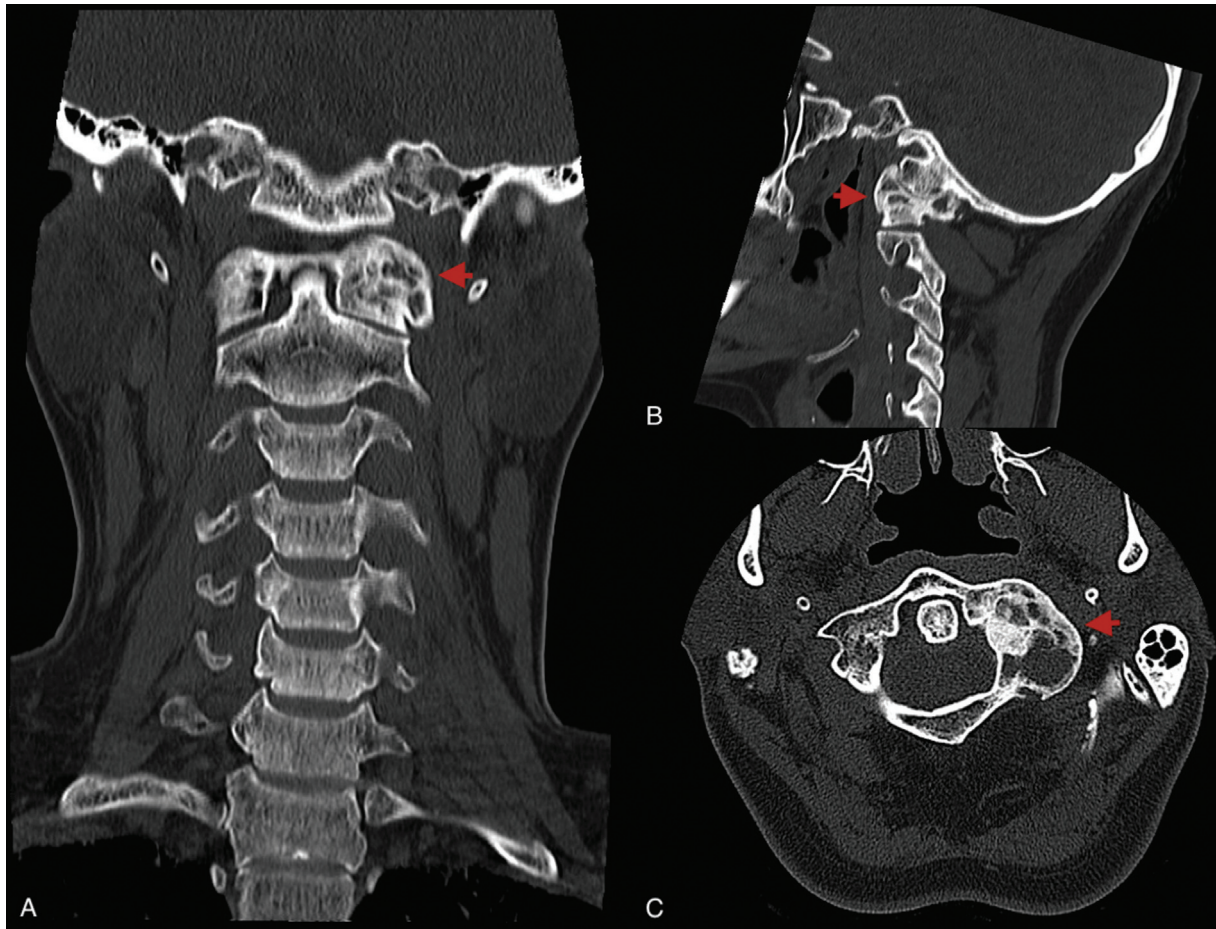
Cervical computed tomography scan with no contrast four months into the treatment. Coronal (A), sagittal (B), and axial (C) sections showing signs of early corticalization within the lesion.
